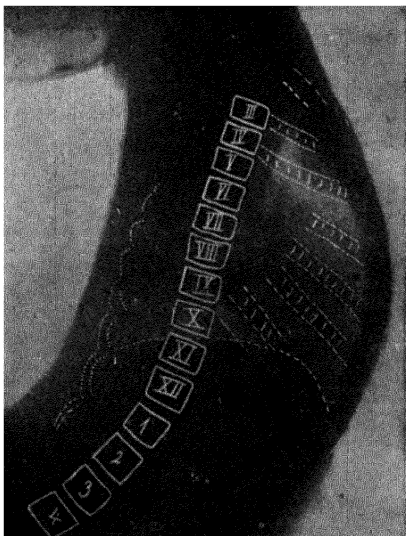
The supple 13-year-old boy in Fig. 214 X-rayed in the position. The dorsal spine has kept a slight convexity in a backward direction, indicating that the upper dorsal extensors are not working very hard in this position with the upper trunk vertical.
